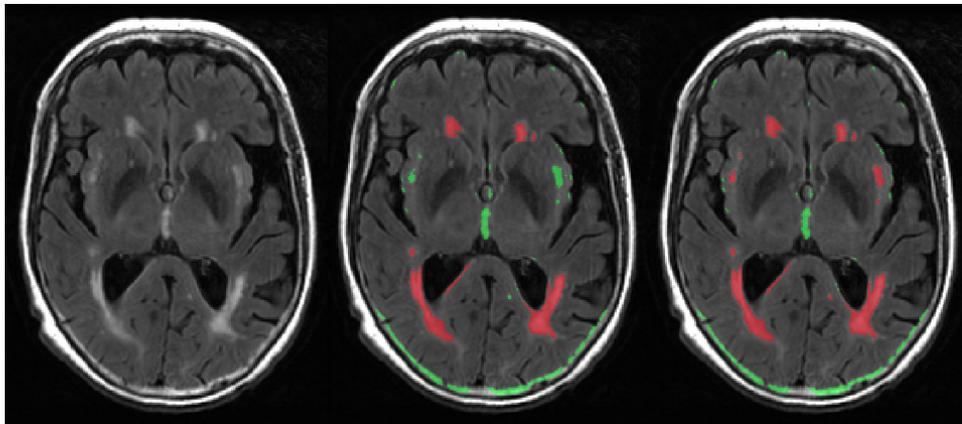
Axial FLAIR (left), with automatically generated lesion overlay (center), and manually edited lesion (red) overlay (right).
